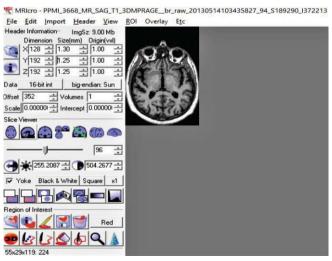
Visualization of the PD affected MRI image in MRIcro tool
